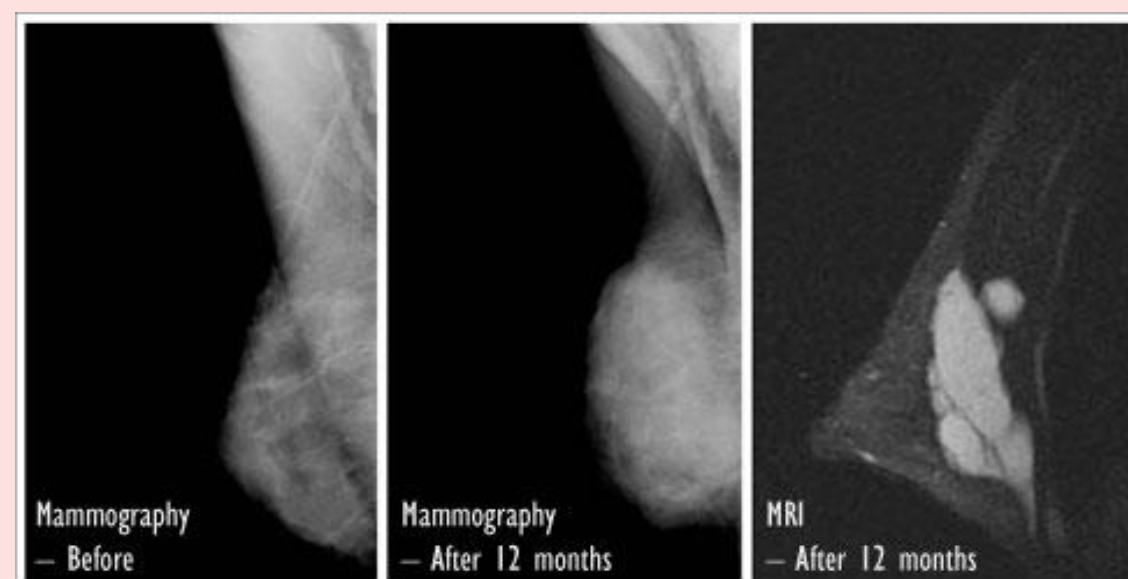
Mammography is inconclusive, however, Macrolane™ deposits seen on MRI.
